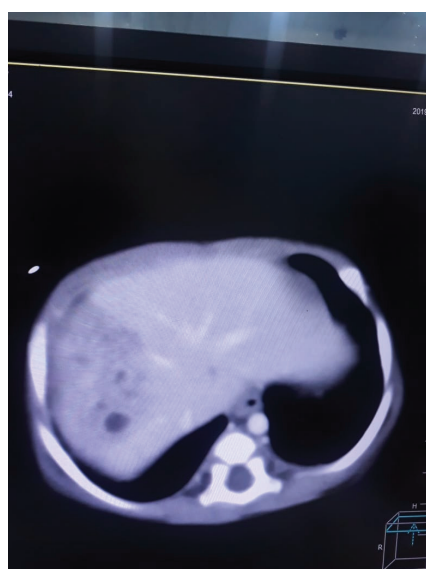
CT of the abdomen showing multiple heterogeneous density areas with internal cystic spaces in the right lobe of the liver.
